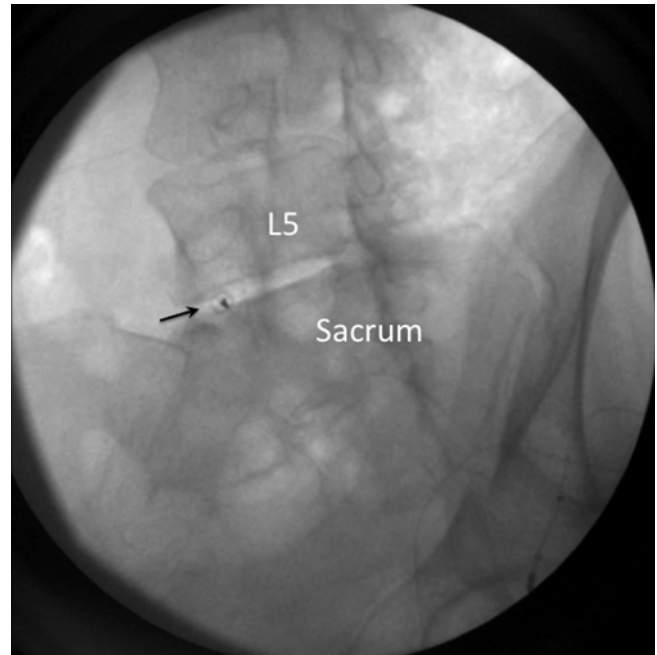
Oblique radiograph of the lumbosacral junction. The spinal needle (indicated by the *arrow*) was inserted with transdiscal technique evident with the end-on view. Thus, only one needle inserted was required as this technique allowed the needle to reach the anterior aspect of lumbosacral junction (With permission from Philip Peng)
